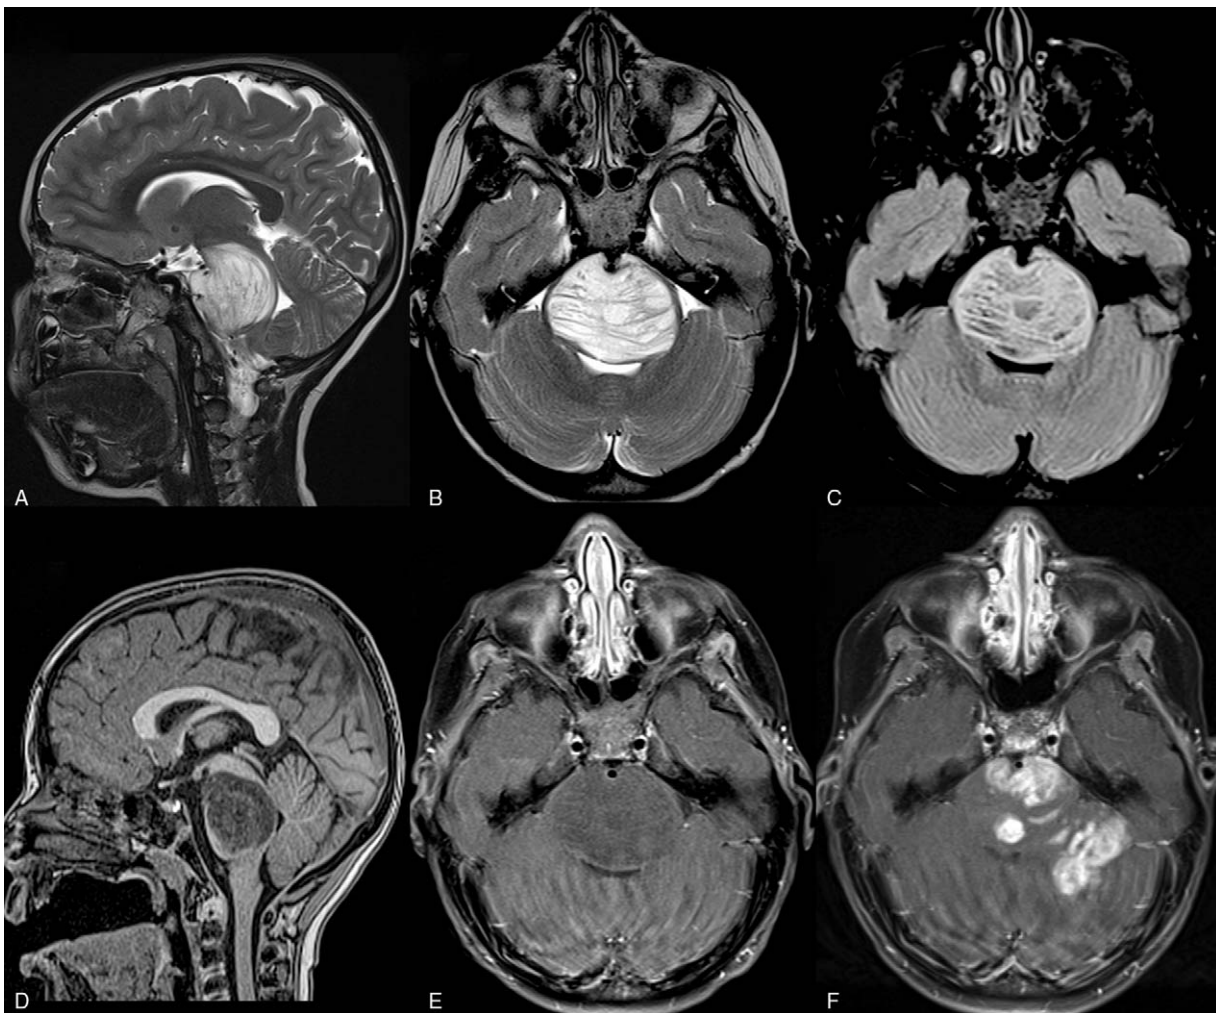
A 5-year-old patient with diffuse midline glioma, H3K27M-mutant in the pons, which had presented with headache and cranial nerve symptoms. Traditionally, these have been referred to as diffuse intrinsic pontine glioma (DIPG). A–D, Sagittal T2, axial T2, axial FLAIR, and sagittal T1 images show an expansile mass centered within and involving almost the entirety of the pons. There is partial encasement of the basilar artery. E, Axial postcontrast T1-weighted images does not show contrast enhancement in this tumor. F, Follow-up imaging at 6 months shows areas of avid contrast enhancement and extension of the neoplasm.
